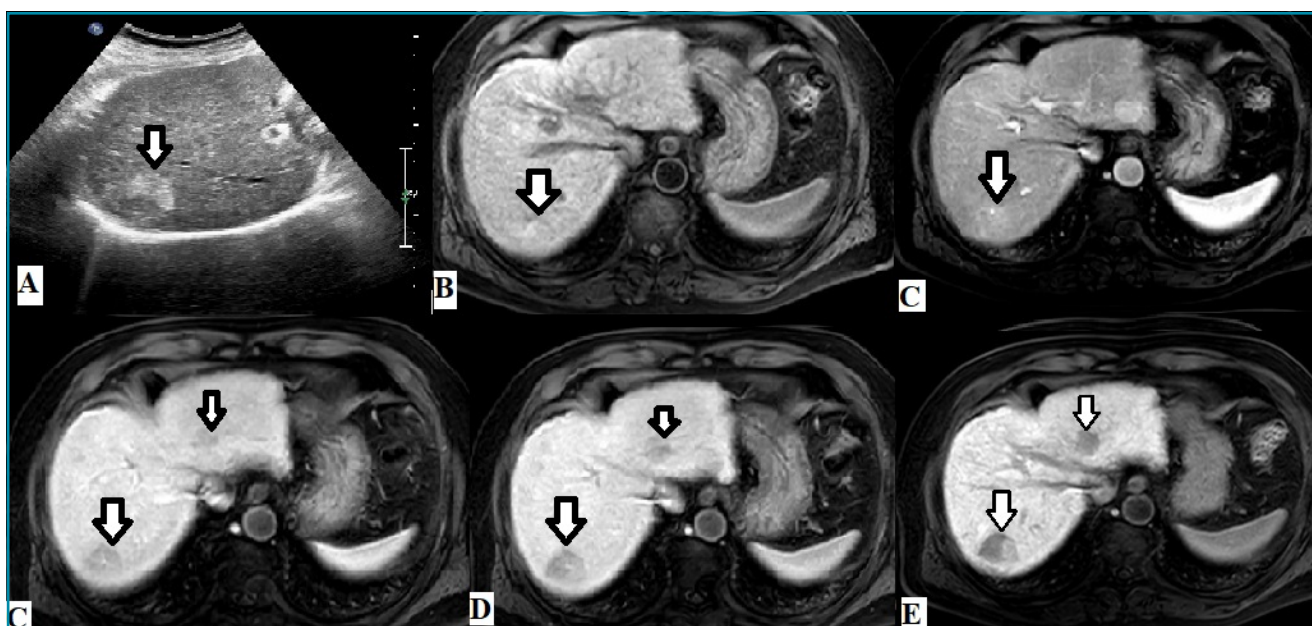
(A) A hyperechoic lesion with hypoechoic areas at segment 7 on ultrasonography (another hyperechoic lesion is not shown). (B) The lesion is slightly hyperintense on the axial T1-weighted image. (C), (D), and (E) Axial T1-weighted image shows arterial hyperenhancement and wash out in portal and venous phases. (E) Hepatobiliary phase lesions are hypointense. Images of a 70-year-old man with hepatocellular carcinoma.
